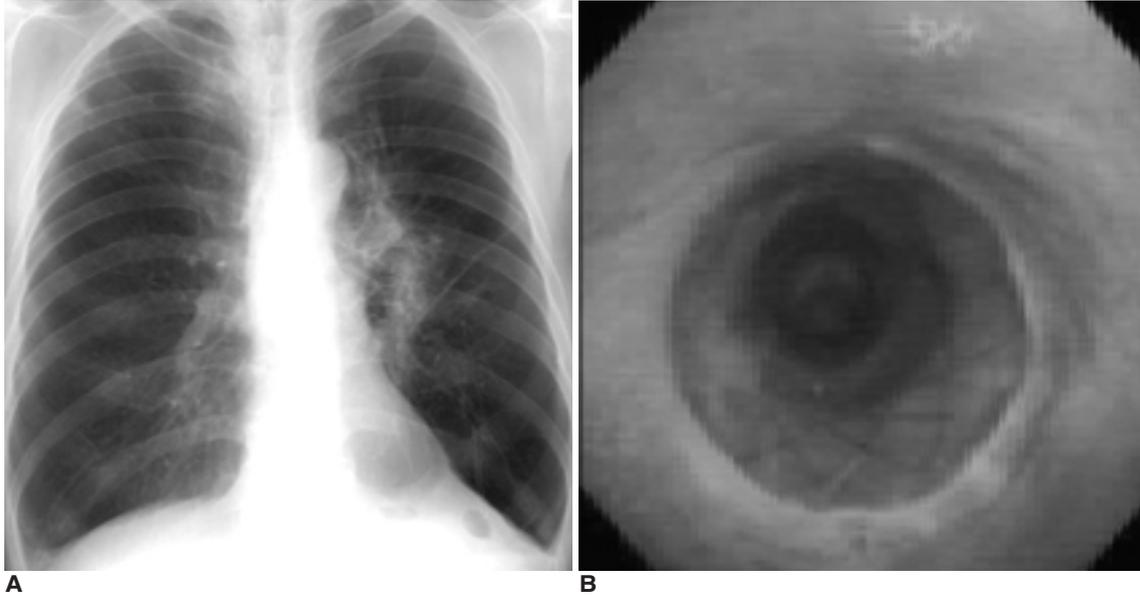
A, B. Chest radiograph (A) and bronchoscopic photograph (B) four months later show complete disappearance of the left lung atelectasis and patency of the stent.
